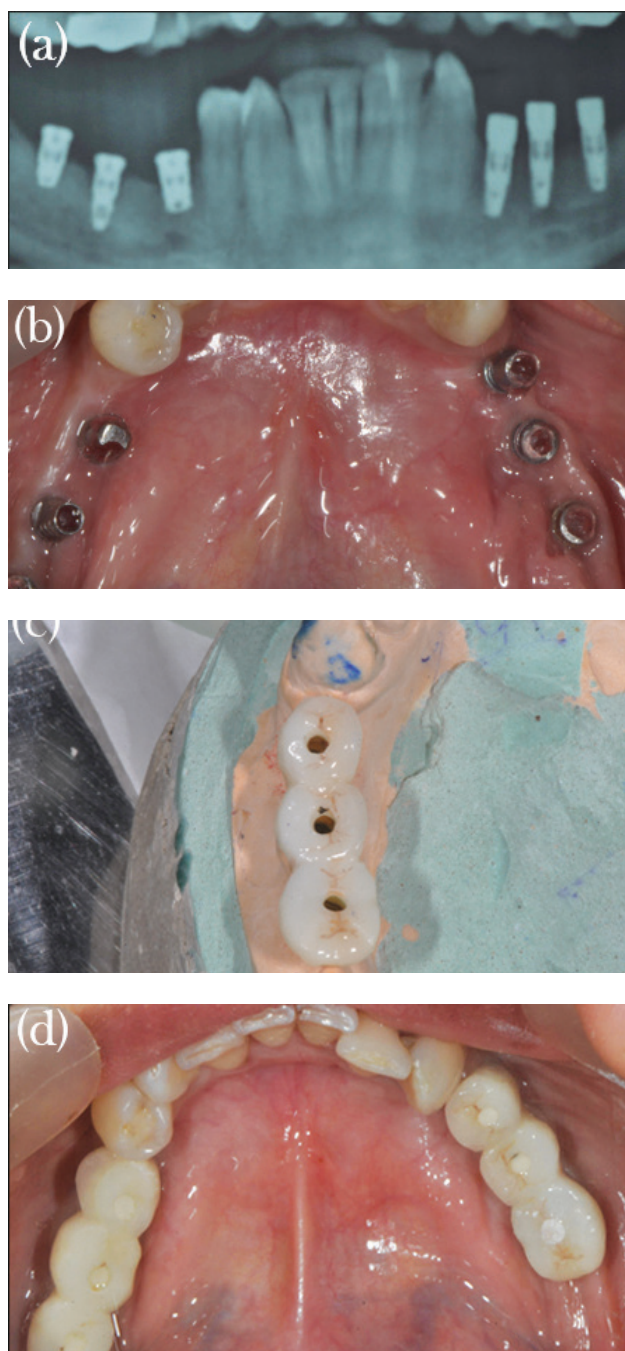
Three implants placed bilaterally on each side, short on left side, standard on right side (a). Baseline radiograph (b). Clinical view of prosthesis bilaterally (c). Picture showing the screw retained prosthesis (d).
